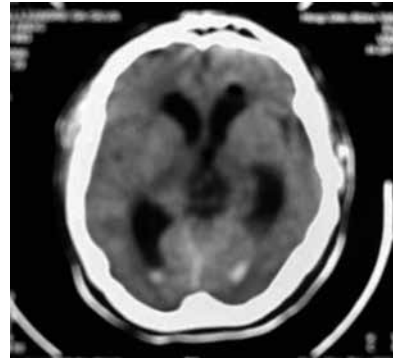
Head CT without contrast, realized after neuroendoscopy, showing an intraventricular (3rd ventricle) heterogenic nodular lesion, with evidence of intraventricular hemorrhage and frontal pneumocephalus.
